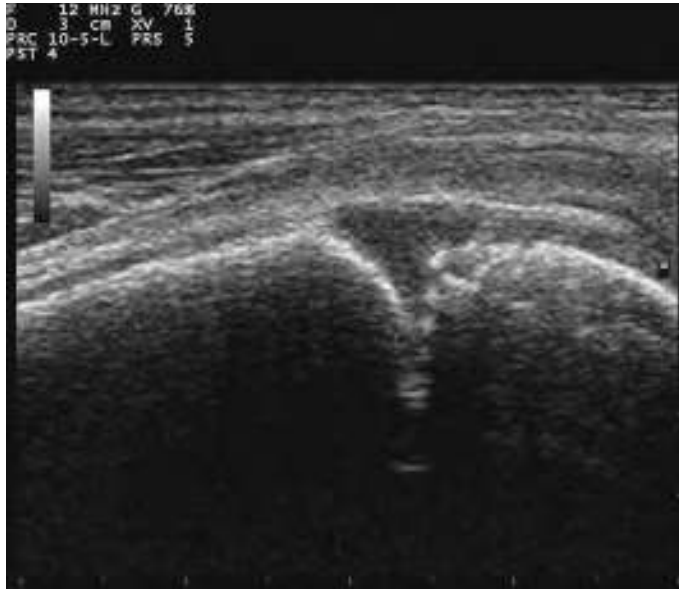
Ultrasound of a joint. Note the “seagull sign,” which is a V-shaped hypoechoic area surrounded by hyperechoic bone. (Used from Devit Dilmen from www.commons.wikimedia.org.)
